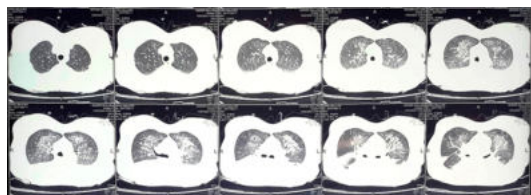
High Resolution CT Scan of Thorax suggesting Acute Respiratory Distress Syndrome
